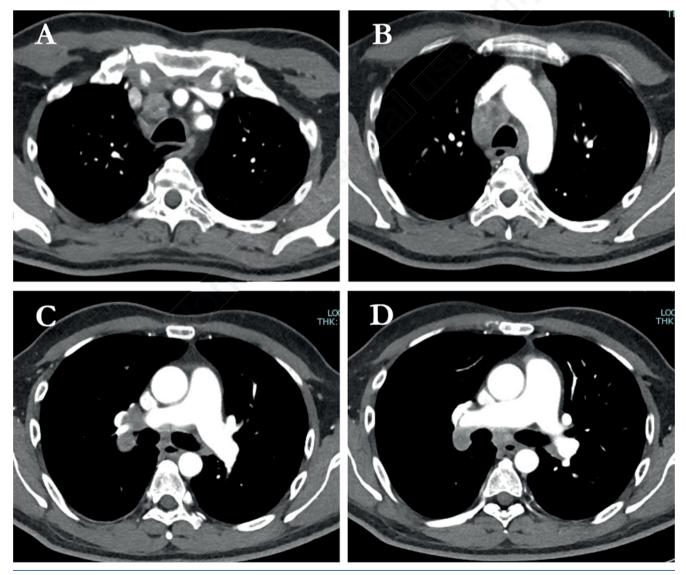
Chest computed tomography scan showing right paratracheal (A, B), paraaortic (B), right hilar (C, D) and subcarinal (D) lymph adenopathies.
